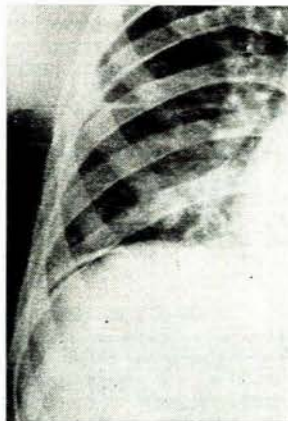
X-ray photo of abdomen and chest (case 1) shows: right basal pulmonary compression atelectasis; free air under the right diaphragm; oedematous thickening of diaphragm; and intraperitoneal free fluid.
